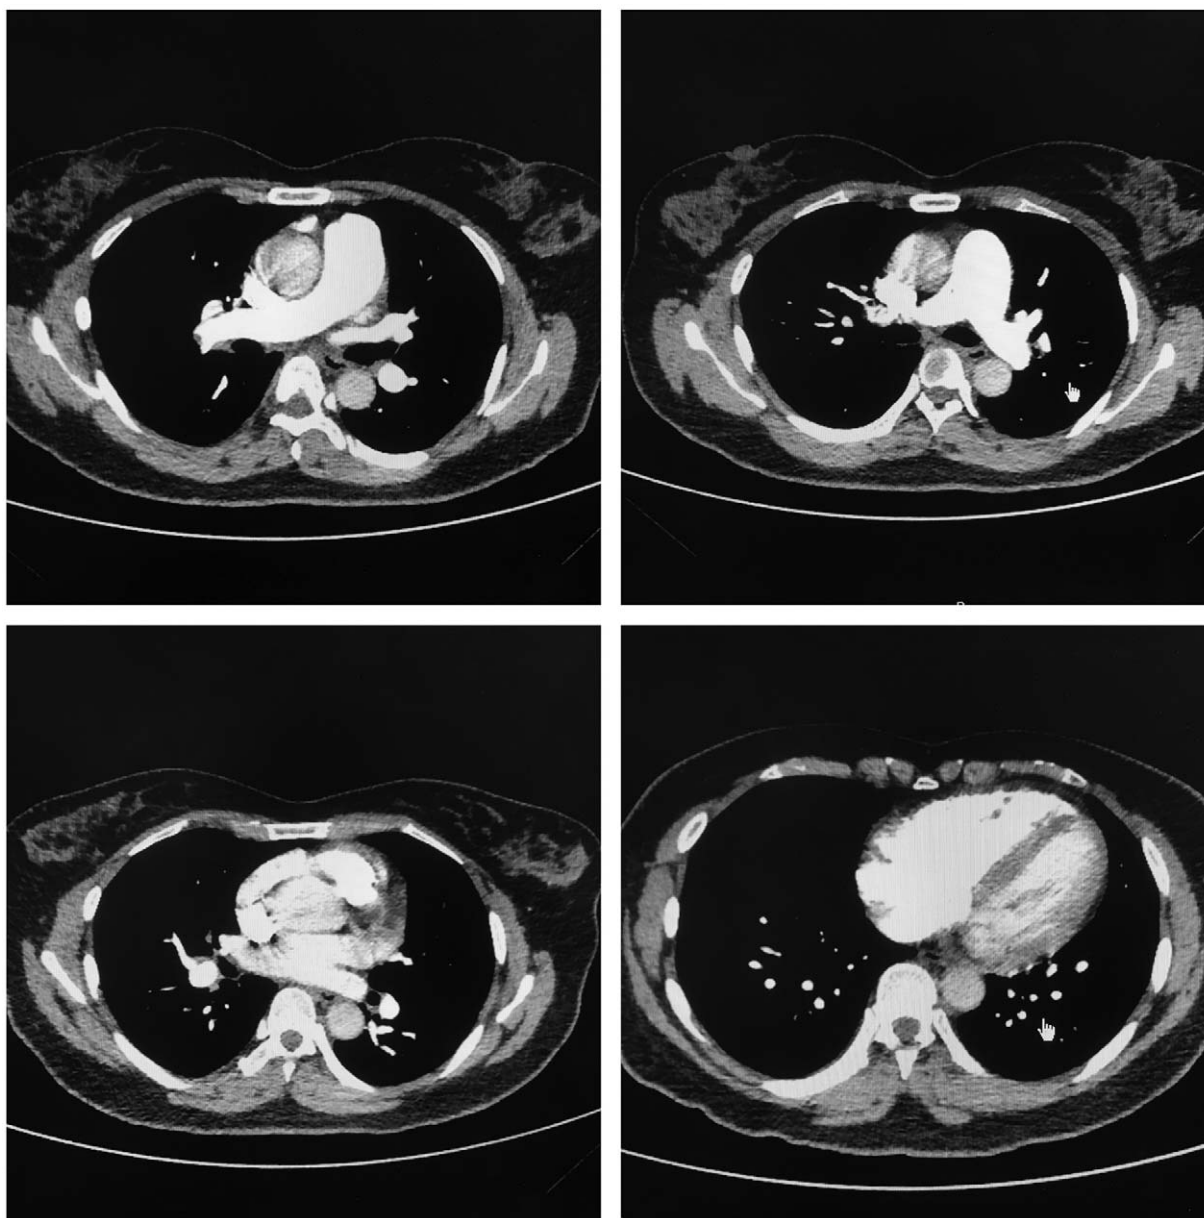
Computed tomography (CT) pulmonary angiography revealed mural thrombus in the right and branches of the left pulmonary arteries. CT= computed tomography.
